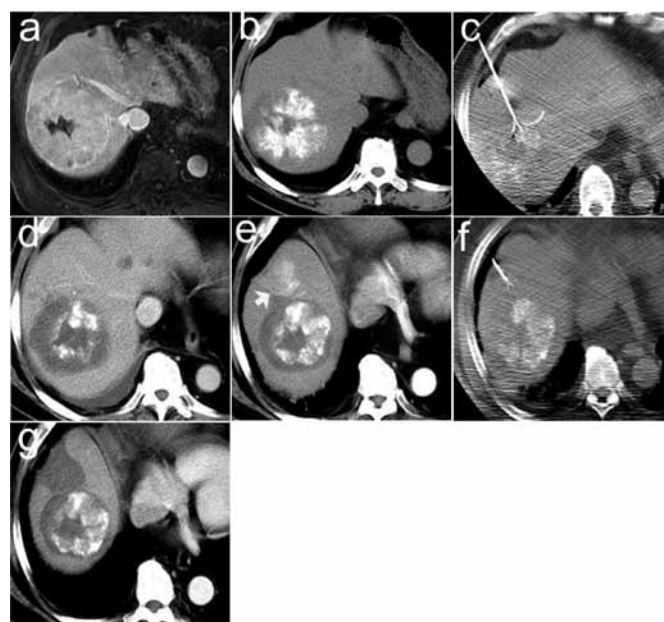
A selected case from this study. (a) MRI scan of the tumor prior to treatment; (b) CT scan of the tumor following TACE; (c) CT scan from the procedure of repeated RFA (central massive destruction with the StarBurst Xli-enhanced RFA electrode); (d) CT scan of the first complete ablation; (e) local tumor progression following initial complete ablation (white arrow); (f) peripheral ablation with StarBurst XL RFA electrode; (g) CT scan of the tumor at the end of this study (complete ablation was achieved).
